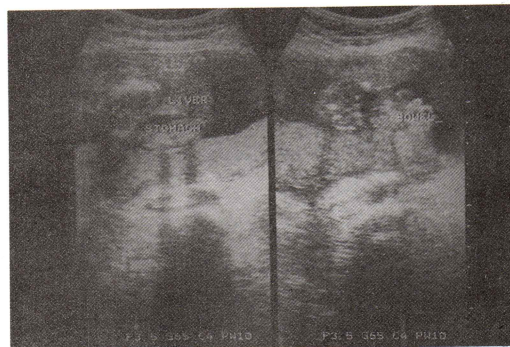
Sonogram of fetus with body stalk anomaly shows herniated viscera and in proximity with the placenta. The umbilical cord could not be identified (Case 2).
